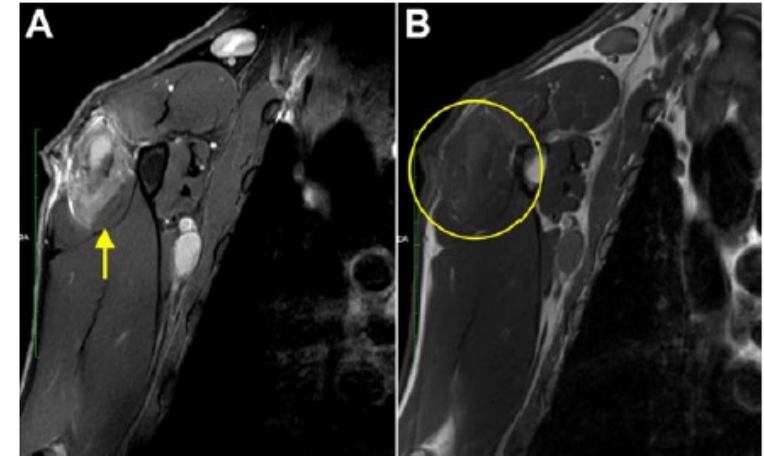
Magnetic resonance imaging (MRI) at 28 days after surgical tendon release. (A) Sagittal view of T2-weighted fat-saturated turbo spin echo MRI showing edema of retraction in the infraspinatus muscle (arrow). (B) Axial view of T1-weighted MRI showing a “ground glass” appearance of the infraspinatus muscle with a blurred aspect and slight hyperintense signal (circle).
